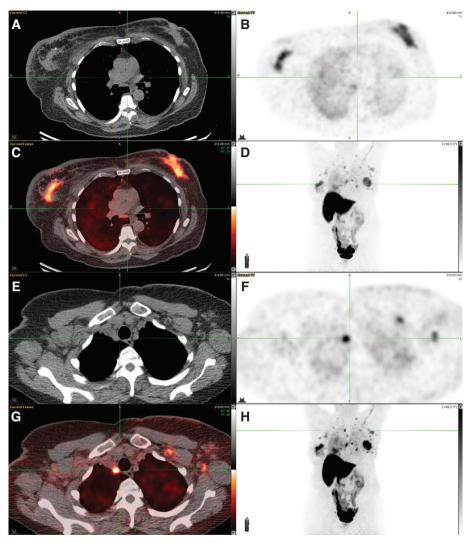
18F-FES PET/CT in carcinoma breast. 18F-FES PET/CT in a patient with initially diagnosed left breast invasive ductal carcinoma (IDC), cT1cN0, ER+/PR+/HER-2 negative, Ki67 11%. Initially declined treatment and now with bilateral breast masses with Ki67 20%, bilateral lymphadenopathy, and pulmonary nodules. Images include: (A) axial CT, (B) axial FES PET, (C) fused axial PET/CT, (D) maximum intensity projection (MIP) image, (E) axial CT, (F) axial FES PET, (G) fused axial PET/CT, and (H) MIP image. 18F-FES PET/CT demonstrates increased FES uptake in the bilateral breast masses (images A-D), lymph nodes in the bilateral axillae, subpectoral regions, and mediastinum (images E-H), and bilateral pulmonary nodules (lung windows not included).
